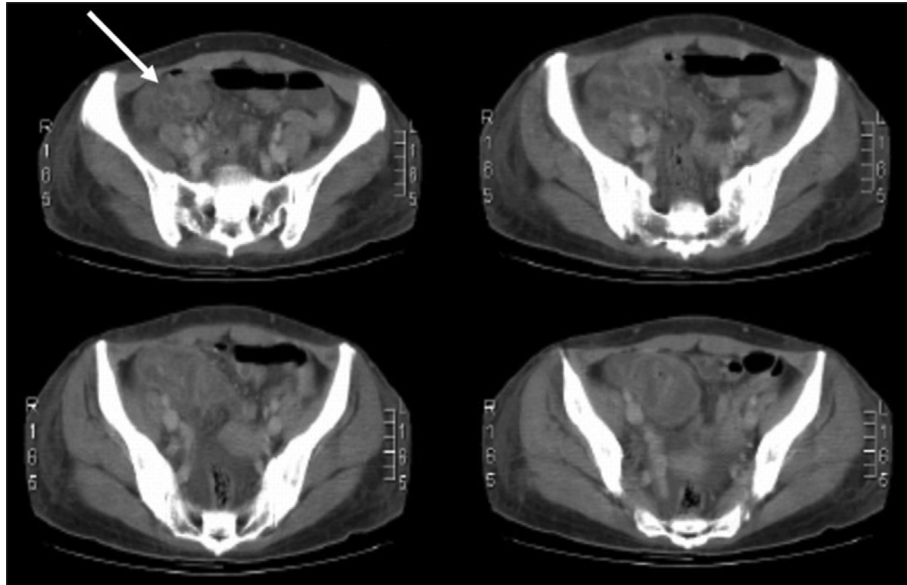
Abdominal computed tomography showed cecal tumor (arrow) and intra-abdominal abscess.
